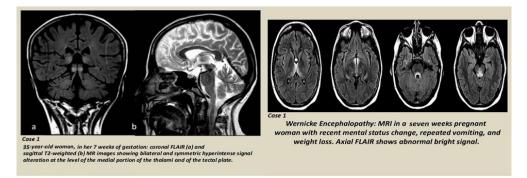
MRI findings of Wernicke's encephalopathy
